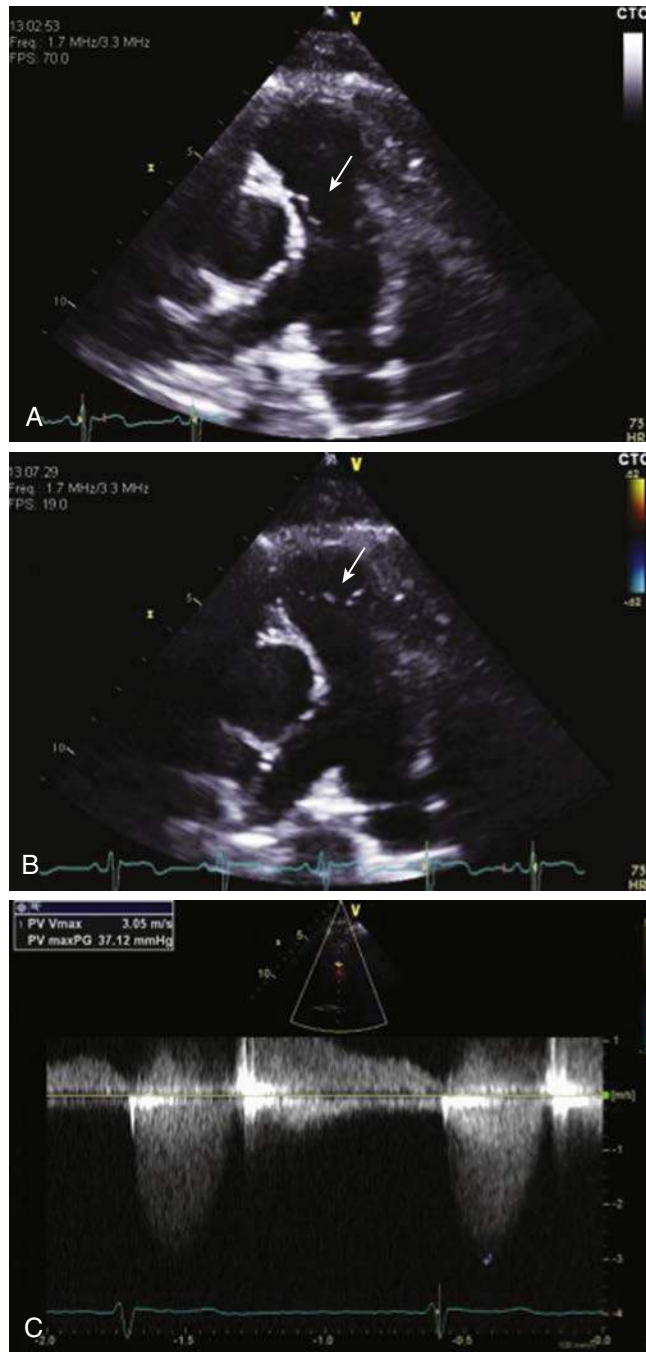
A and B, Parasternal short-axis 2D echocardiography of a dome-shaped pulmonary valve (white arrow) during systole (A) and diastole (B), with a post-stenotic dilation of the pulmonary trunk and the left pulmonary artery. C, Continuous wave Doppler assessment across the pulmonary valve, showing a maximal velocity of 3 m/s, corresponding to a maximal systolic gradient of 37 mm Hg.
